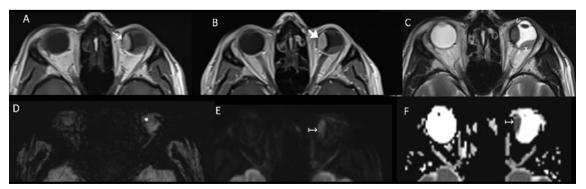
Left choroidal ocular melanoma, in a 41-year-old male patient with a history of progressive blurred vision in the left eye. Axial MRI images (A–F) showed a left intraocular fusiform lesion in the choroidal retinal nasal wall, with spontaneously hyperintense signal on T1WI (thin white arrow in A), with no apparent contrast enhancement (thick white arrow in B). There was low signal intensity on T2WI (white arrowhead in C), a susceptibility artifact on SWI sequence (* in D) and restricted diffusion (\mapsto in E and F). The melanoma was also associated with retinal detachment (x in C).
